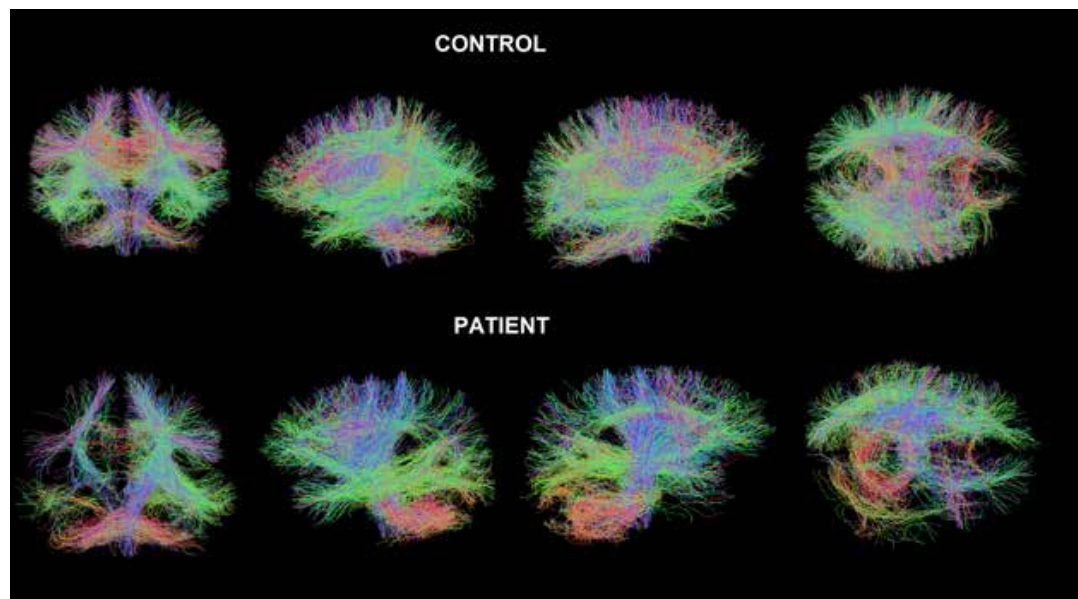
Neural tracks obtained with DTI in a healthy control (top) and a patient in MCS (bottom) confirms the structural damage which is evident in the temporo-parietal regions of the right hemisphere (bottom right - T1 MRI structural image). Colors indicate directionality of water diffusion: red = left-right; green = anterior-posterior; blue = superior-inferior.
